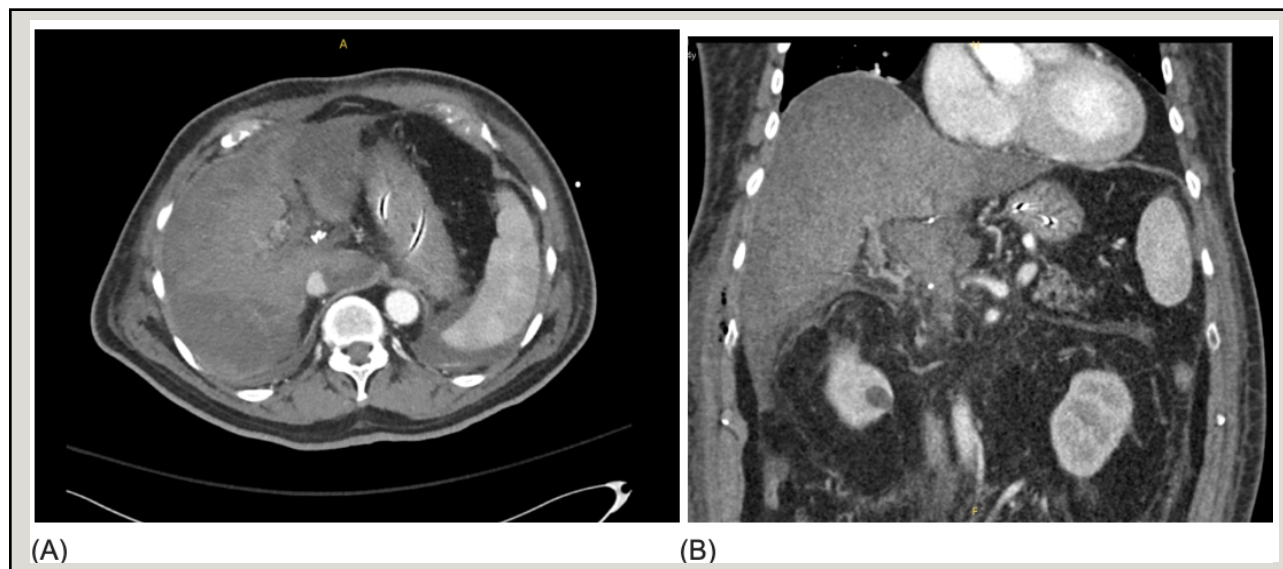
Upon admission, CT with contrast imaging of patient's abdomen was performed, showcasing large common hepatic artery aneurysm in 2 views. (A) Transverse View. (B) Coronal View.
